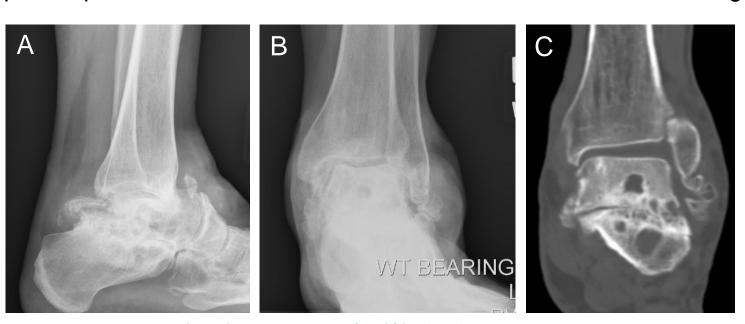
Initial x-rays (A, B) and coronal CT (C) of left ankle, showing cystic changes in the talus and calcaneus, varus tilt with reduced height of the talar body, and a preserved ankle joint.
